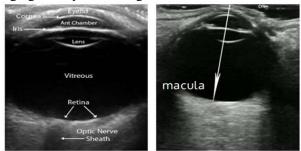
Normal anatomical landmarks of the eye on ultrasonographic imaging
